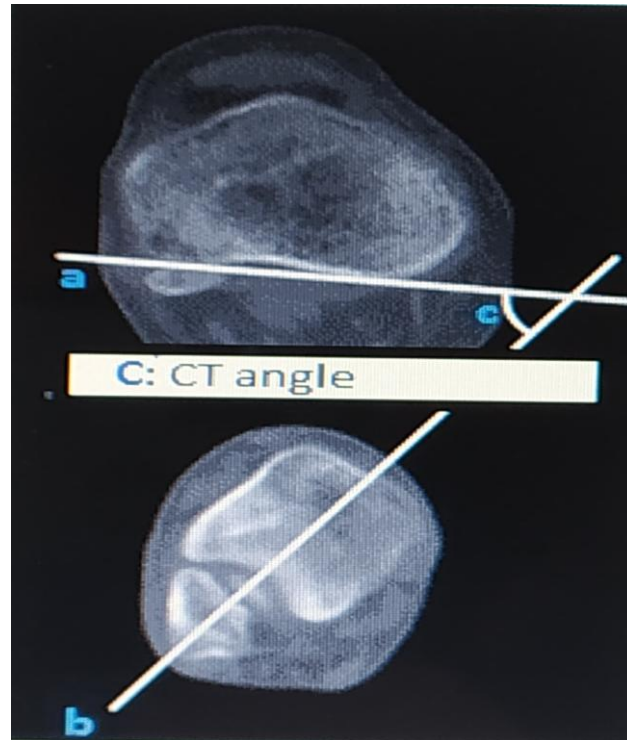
a: Tibial Proximal Transverse Axis, b: Lateral Malleolar Axis, c: CT-based angle.
